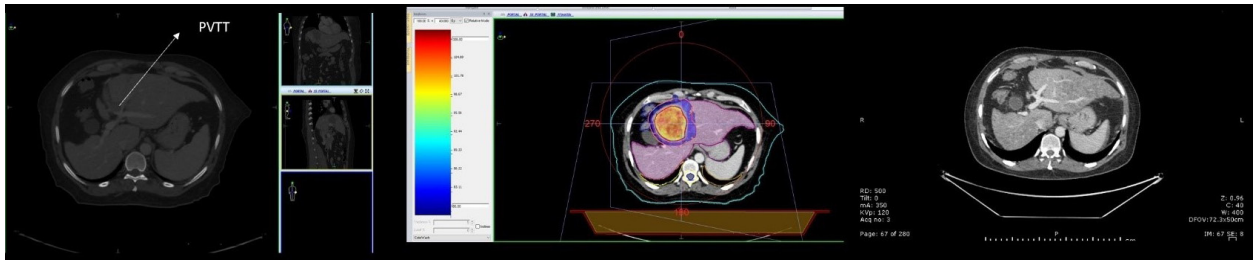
Portal vein recanalization. A. The pre-SBRT scan with portal vein tumor thrombosis (PVTT) involving the confluence of the portal veins, the same thrombus was extending into the main portal vein a Vp4 thrombus; B. The isodose distribution of a full arc the volumetric modulated arc therapy (VMAT) plan; C. Contrast-enhanced computed tomography (CECT) at the same level showing a complete resolution 6 months post stereotactic body radiation therapy (SBRT). This patient underwent a liver transplant and is disease free
